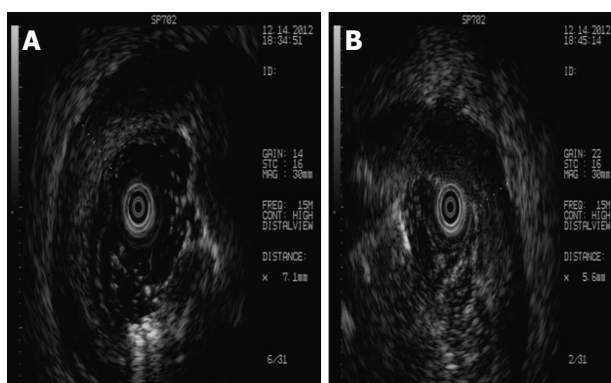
Endoscopic ultrasonography showed ulcers and necrosis in the depth of the mucosa or submucosa (A) and circumscribed mucosal thickening (B). The image shows a characteristic change of chronic nonspecific inflammation, but not malignant lymphoma.
